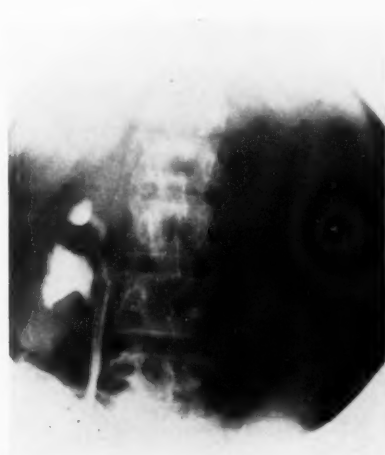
Upper urinary tract of Case III, showing two pelves, one of them being distinctly rudimentary in size and contour. (X-ray work by Dr. A. L. Gray, Richmond, Va.)
